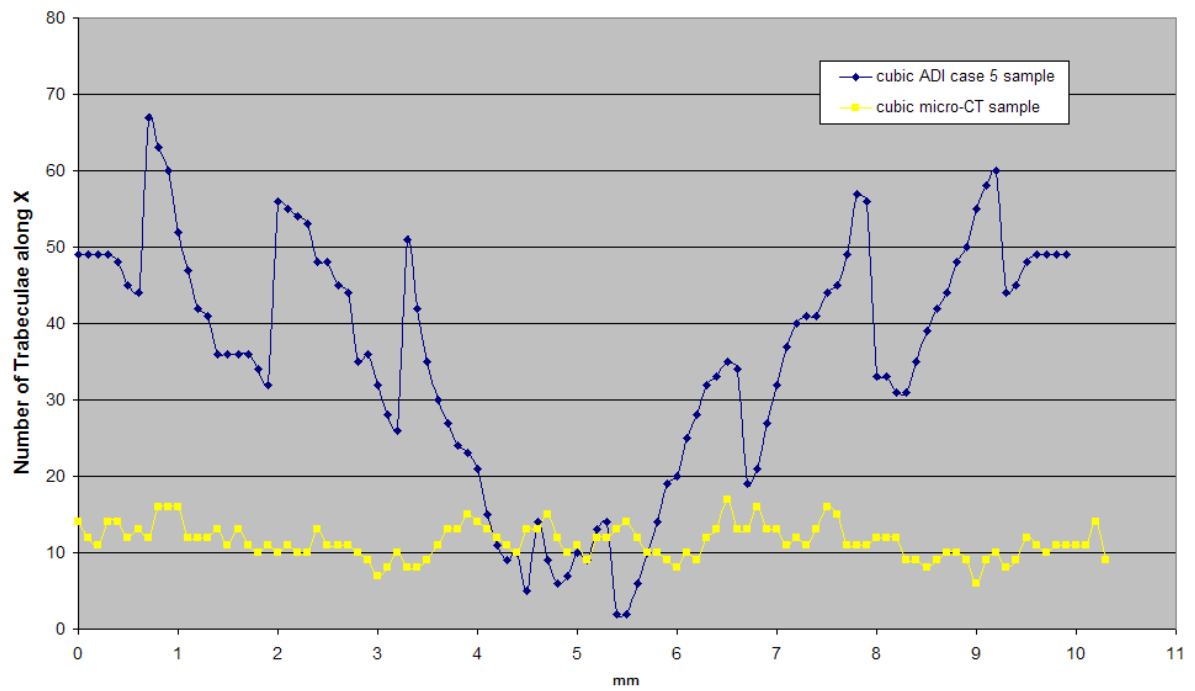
Comparison of trabecular area along X between the cubic ADI case 5 sample and cubic  $\mu$ CT sample
